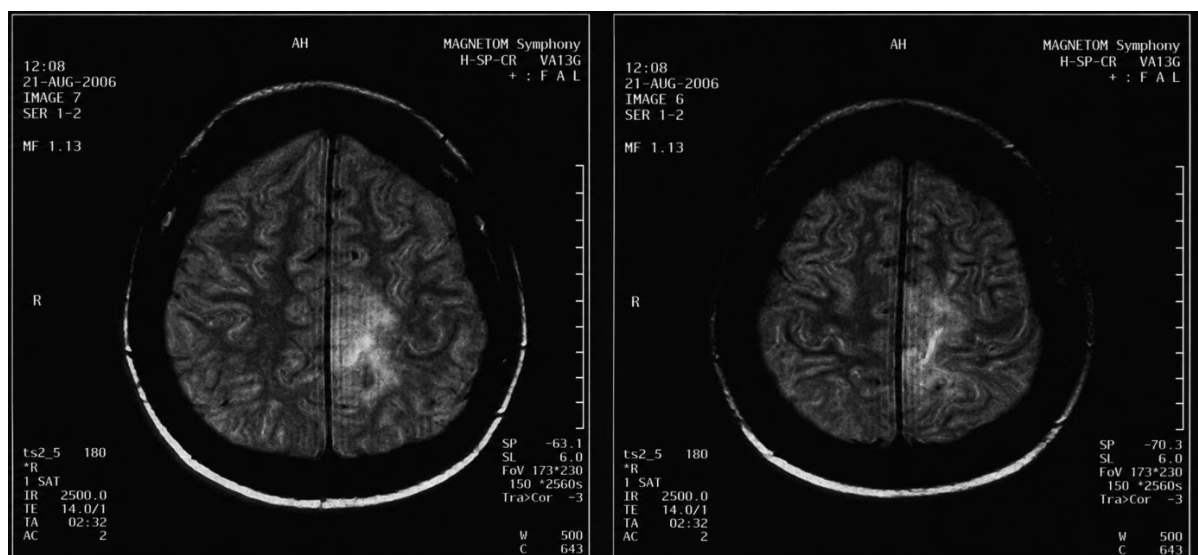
MRI sections of the same brain tumor acquired at different levels. The state of the brain in an MRI scan taken on 21 August 2006.
